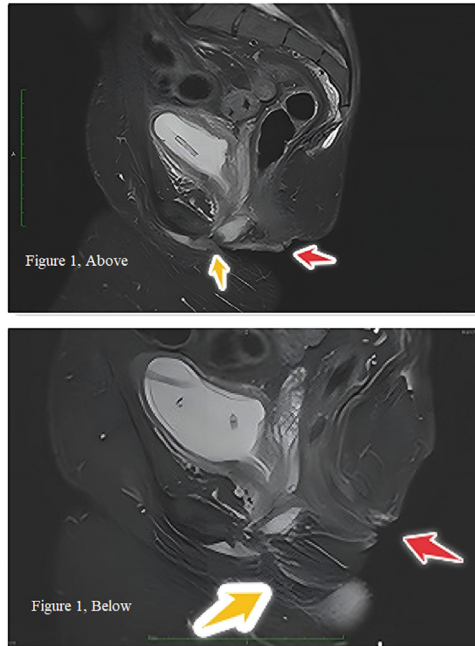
(Above) MRI, (Magnetic Resonance Imaging) T2 weighted fat sat images, preoperative study, sagittal view; it is apparent the cutaneous-urethral fistula, (Yellow arrow); red arrow shows the anus; (Below) MRI, same comparative images, follow-up of 120 days, well-consolidated flap now replacing the debrided scarred tissue and effectively supporting the repaired urethra (Yellow arrow).
